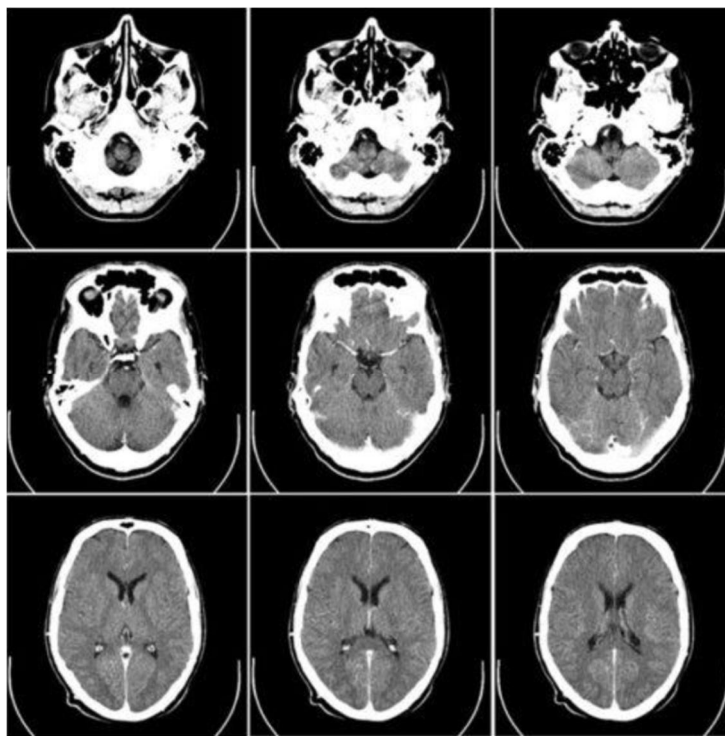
CT Scan image of Human head (Neurologie Zeeland, 2022).
